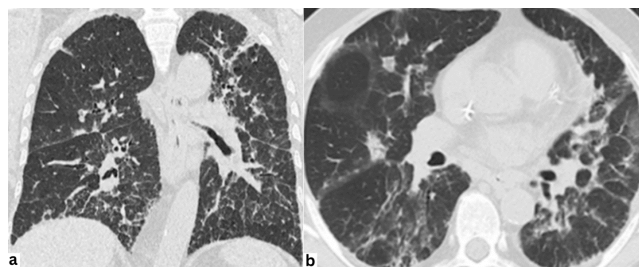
High-resolution chest computed tomography scan: (a) coronal section showing signs of traction bronchiolectasis and ground-glass opacity, absence of an apico-basal gradient, (b) axial section that depicts a ground-glass pattern, consolidations with an air bronchogram, and a distribution that is focused around the bronchioles and extends to the periphery
